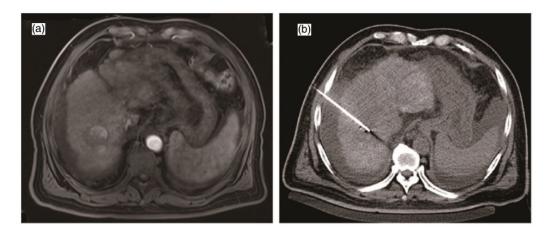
Abdominal magnetic resonance imaging showing a new nidus of hepatocellular carcinoma in the right liver lobe, after which computed tomography (CT)-guided radiofrequency ablation (RFA) was performed. (a) Abdominal contrast-enhanced magnetic resonance image showing an abnormal nodular signal in the right lobe near the roof of the liver and blood supply during the arterial phase. (b) The patient underwent CT-guided RFA. The RF electrode needle (16 cm/3 cm; Lide, Mianyang, Sichuan, China) punctured the preset area according to the proposed path, and CT confirmed that the scope of the needle tip was within the lesion.
